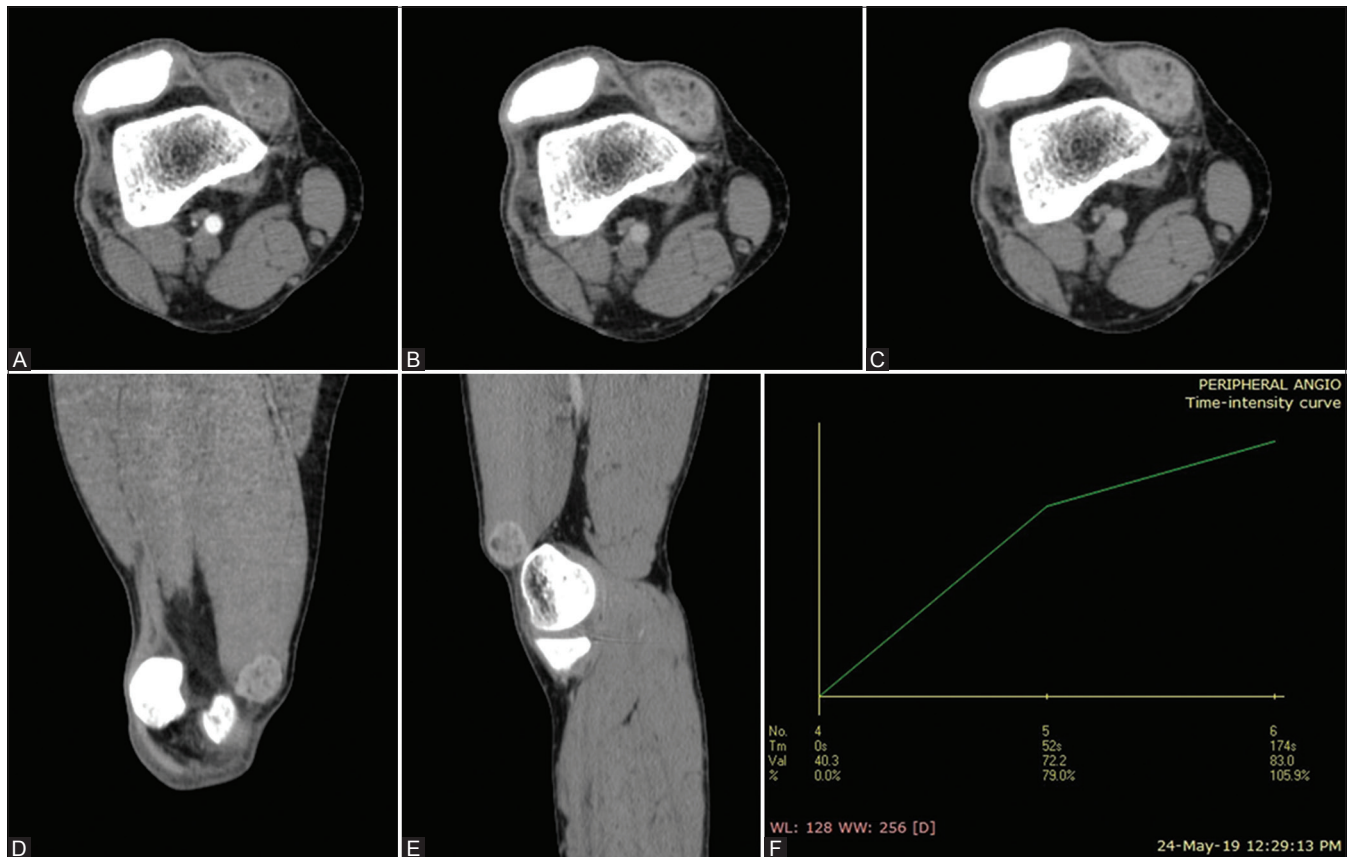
(A-F): Triple phase axial CT images showing minimal central vessel enhancement in the arterial phase (A) with increasing parenchymal enhancement in the portal (B) and equilibrium phase (C) technical correction by Authors is required. The lesion shows type I enhancement curve on time density graph (F). Coronal and Sagittal images (D and E) showing the lesion in vastus medialis muscle
